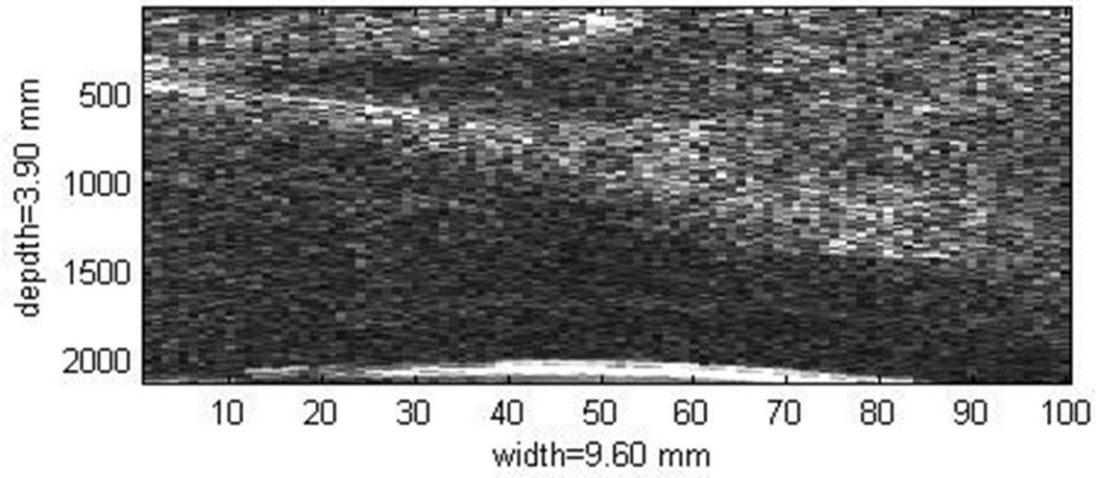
B-mode ultrasound image of gel-liver interface.
